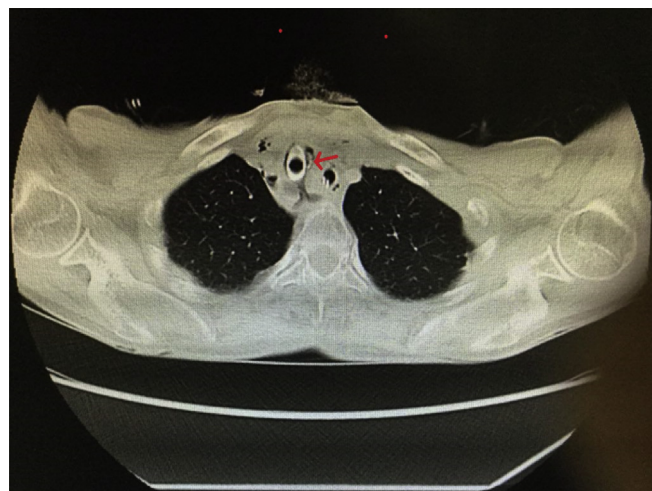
Computerized tomography (CT) scan performed after tracheotomy showing the tracheal membrane (indicated by an arrow) obstructing the tracheostomy tube.
